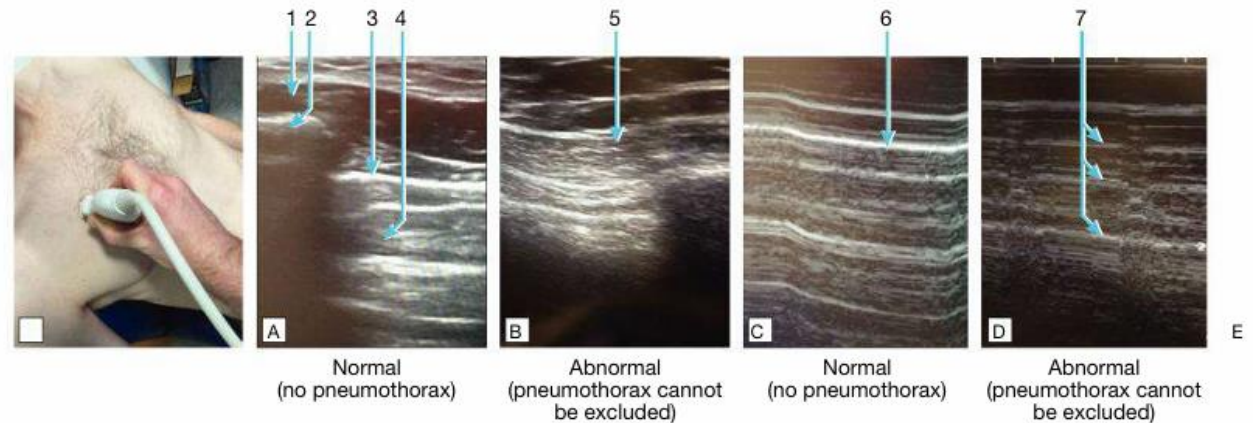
Using ultrasound to rule out an anterior pneumothorax. A Probe position and orientation. B and C Two-dimensional (2D) ultrasound images. D and E M-mode ultrasound images. Key: (1) Intercostal muscle. (2) Rib. (3) Normal bright pleural line – ‘shimmering appearance’ of sliding pleura. (4) Lung. (5) Absent ‘shimmering’ in pneumothorax and lung not visible. (6) Normal – ‘sea shore’ sign excludes pneumothorax at that location. The ‘sea shore’ is represented by the bright granular line with lung (sea) deeper to the bright line. (7) Absent granular pleural line and a repeating linear pattern or ‘barcode’ sign suggest the presence of pneumothorax.
